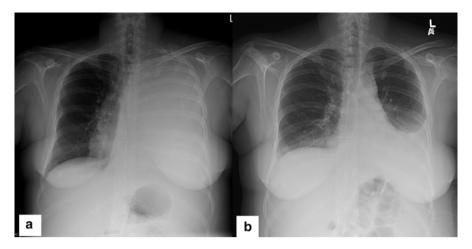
(a) Chest radiograph of a 48-year-old woman with metastatic endometrial cancer demonstrating left hemithorax opacification. Of note is a shift of the trachea to the right owing to massive pleural effusion. (b) Chest radiograph showing subsequent improvement in aeration of the left hemithorax in the patient after placement of a pleural catheter
